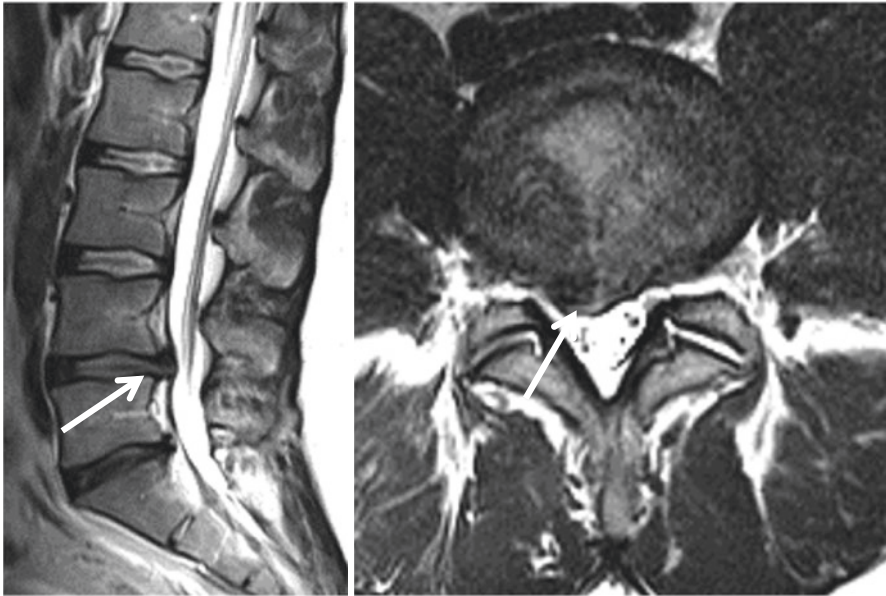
Sagittal and axial T2W MR images show right paracentral disc protrusion
